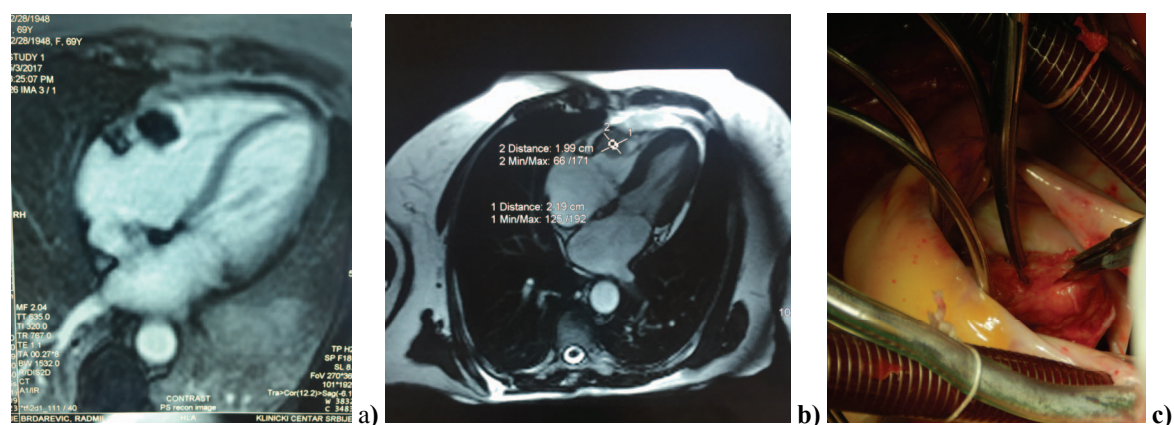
Magnetic resonance imaging (a, b) and intraoperative image (c) showing the hemangioma in the right ventricle.
